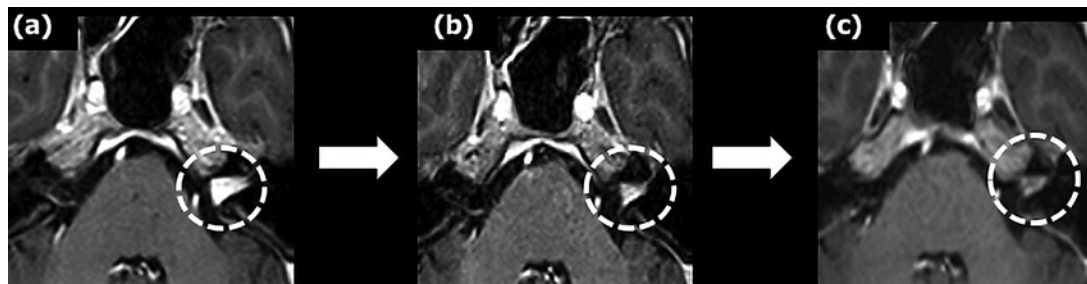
Changes in head contrast-enhanced magnetic resonance imaging (MRI) findings. a Contrast-enhanced MRI scan obtained at diagnosis. The left vestibulocochlear nerve showed a contrast effect (dashed circle), and no brain metastasis could be observed. b Contrast-enhanced MRI scan obtained following 2 cycles of chemotherapy. c Contrast-enhanced MRI scan obtained following 6 cycles of chemotherapy, demonstrating a reduction in the contrast enhancement of the left vestibulocochlear nerve.
